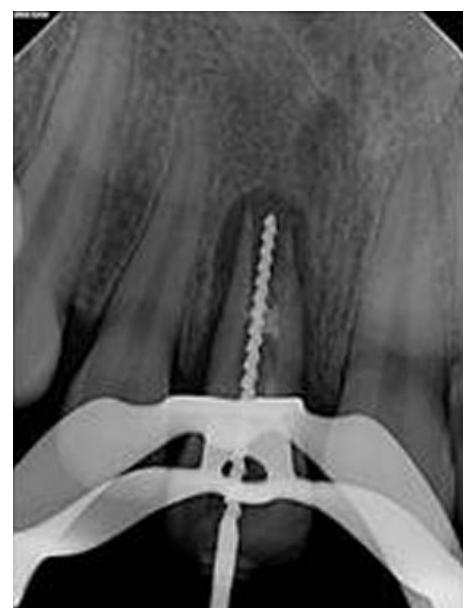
Periapical radiograph of root canal length determination with a size 60 K-file.
